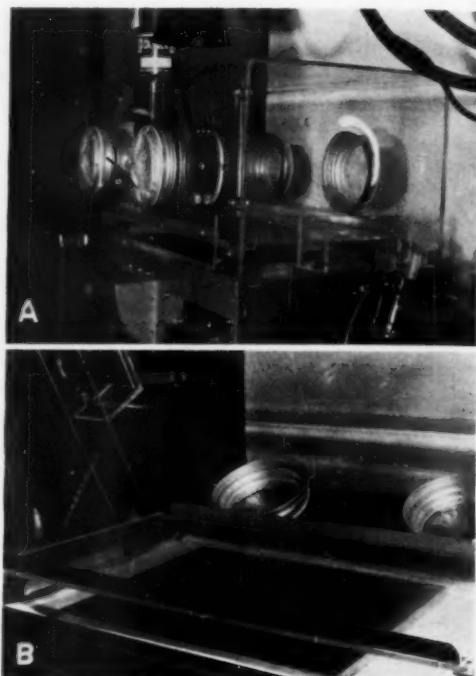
A. Standard incubator with the platform in place. The x-ray cassette is slipped under the platform by utilizing the incubator hood.
